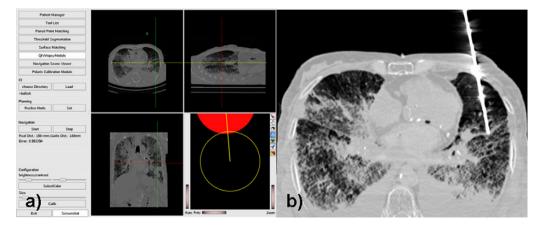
Selecting a target and the biopsy of the lung in the human case 2: (a) Screenshot of the navigation system demonstrates planning of the target in the left lung. Note the two circular targets in the lower right corner; their overlap changes the colour gradually to green and indicates a correctly directed needle; (b) Angulated CT image shows needle inserted into the left lung before the biopsy.
